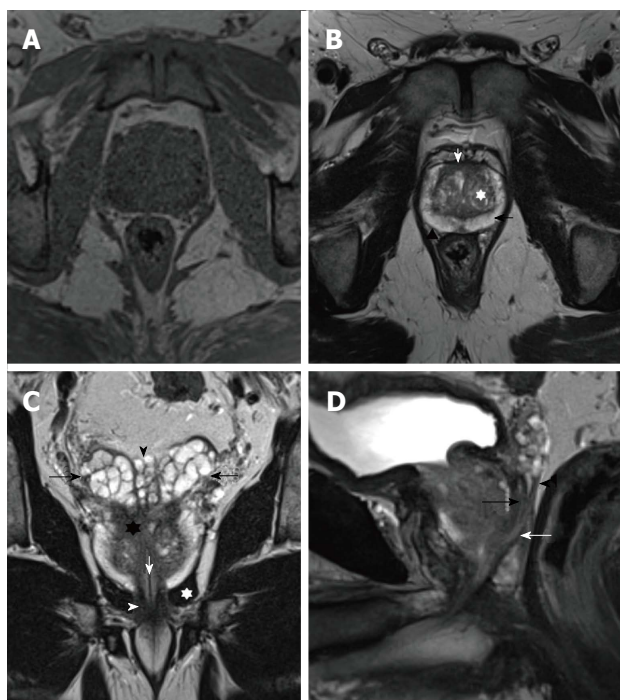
Normal prostate anatomy on magnetic resonance imaging - T1 and T2-weighted images. A: T1-weighted axial image of a normal prostate: Homogeneous gland, isointense to the adjacent pelvic muscles. It is not possible to differentiate any anatomical detail; B: Axial image of the prostate shows peripheral zone (PZ - black arrow) as a hyperintense area with a U-shape. The transitional zone (TZ - white asterisk) has a hypointense multinodular pattern ("organized chaos"). Anterior fibromuscular stroma (white arrow) is seen as a hypointense area anterior to the TZ and medial to both anterior PZ horns. The "capsule" (arrowhead) is seen as a hypointense rim surrounding the gland; C: Coronal image shows the hyperintense seminal vesicles located cephalad to the base of the prostate (black arrows). Ampulla of vas deferens (VD - black arrowhead) can be seen as paired structures medial to both seminal vesicles (SV). Prostate central zone (asterisk) is seen as a hypointense area located in the base of the prostate gland. Urethra (white arrow), levator ani muscle (white asterisk) and external sphincter (white arrowhead) are also shown; D: Sagittal image shows the vas deferens (black arrow), seminal vesicles (arrowhead) and the ejaculatory duct (white arrow).
